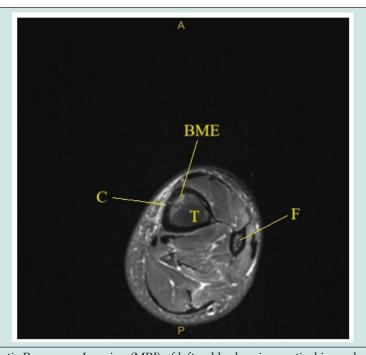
Axial slice of Magnetic Resonance Imaging (MRI) of left ankle showing cortical irregularity (C) within anterior distal tibial metdiaphysis and mild underlying bone marrow edema (BME) suggestive of potential incompletely imaged stress fracture (SF). Tibia (T) and Fibula (F).
